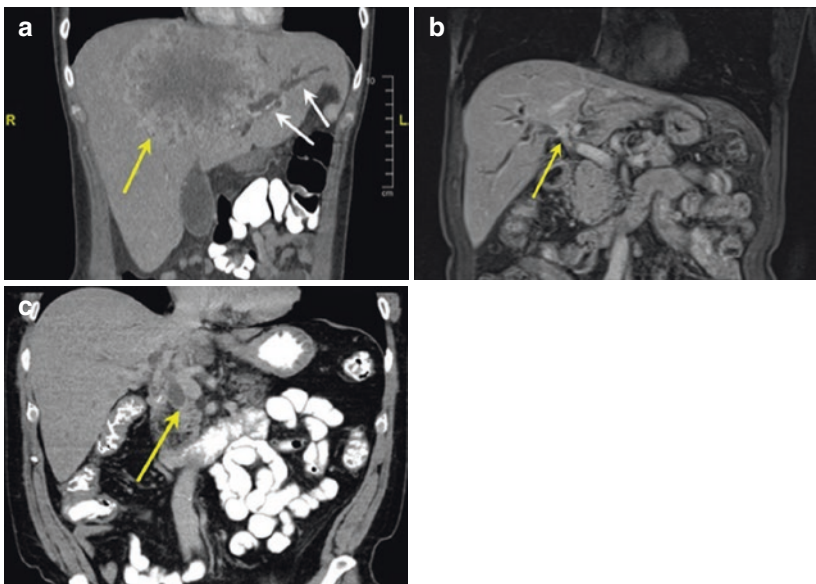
Imaging of cholangiocarcinoma. (a) Computed tomography (CT) of mass-forming intrahepatic cholangiocarcinoma. The yellow arrow demonstrates the peripheral enhancement of the large tumor. The white arrows highlight associated biliary dilation; (b) MRI of perihilar cholangiocarcinoma (yellow arrow); (c) CT of distal cholangiocarcinoma. The yellow arrow demonstrates an abrupt filling defect of the dilated common bile duct
